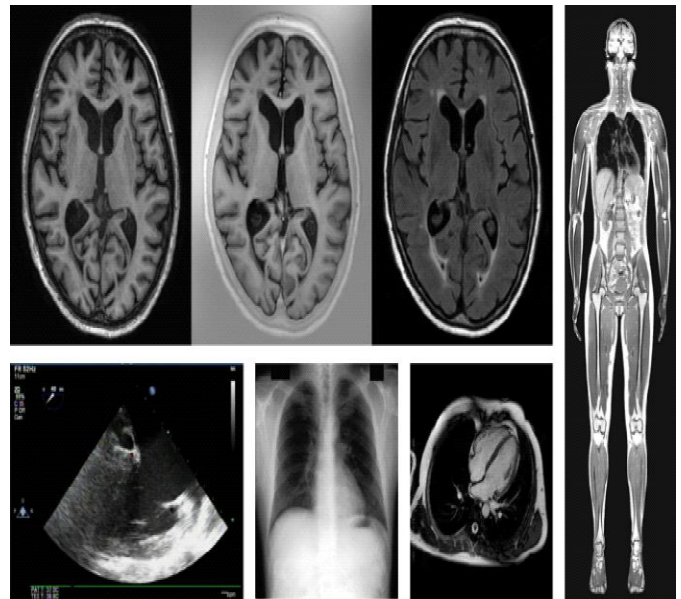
Medical imaging example (upper left to lower right): MRI multiple brain distribution: T1 weight, reverse T1 recovery and FLAIR T2 channel; MRI total wrist; flat heart ultrasound; X-ray chest; MRI heart MRI(Martin et al., 2018)
